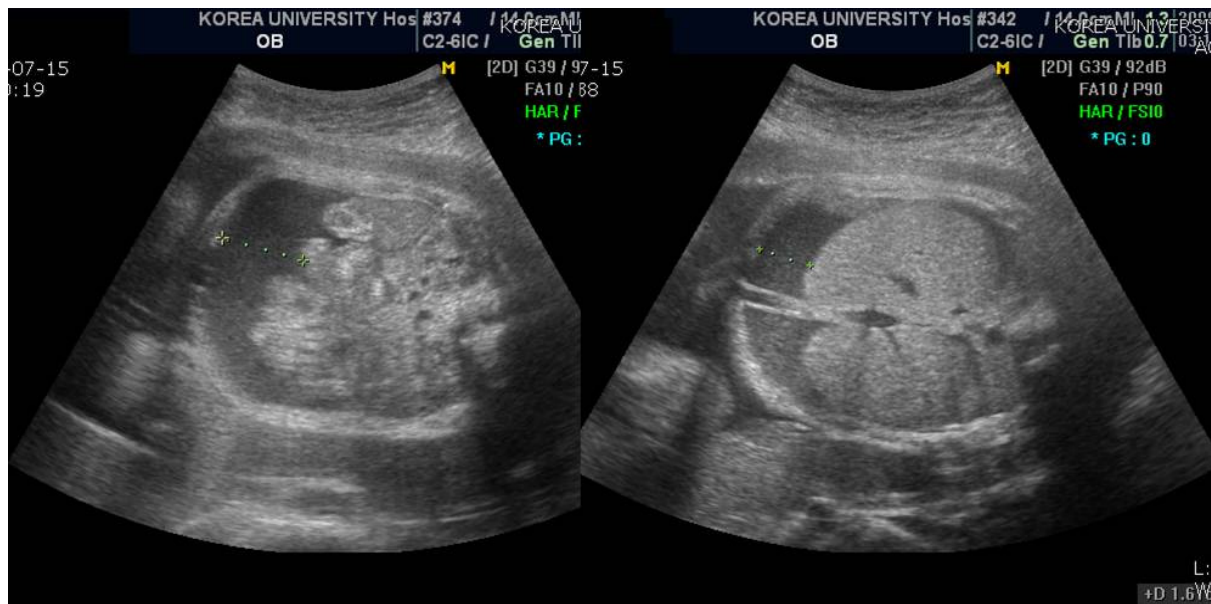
Ultrasonography performed at 30 weeks 6 days of gestation shows massive ascites with focally increased bowel echoes.
